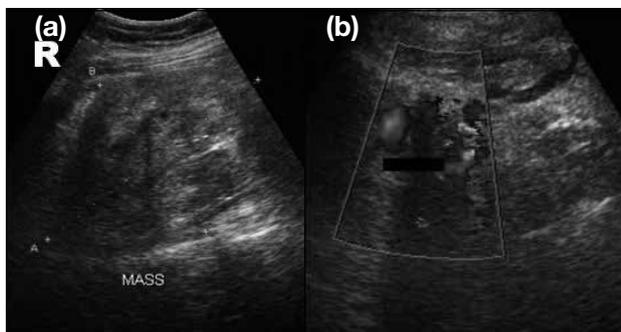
(a) Abdominal ultrasound demonstrating a fairly well-defined large soft tissue mass arising from the left psoas muscle with posterior extension involving the subcutaneous tissue, and (b) colour Doppler demonstrating dilated and tortuous vessels within.
